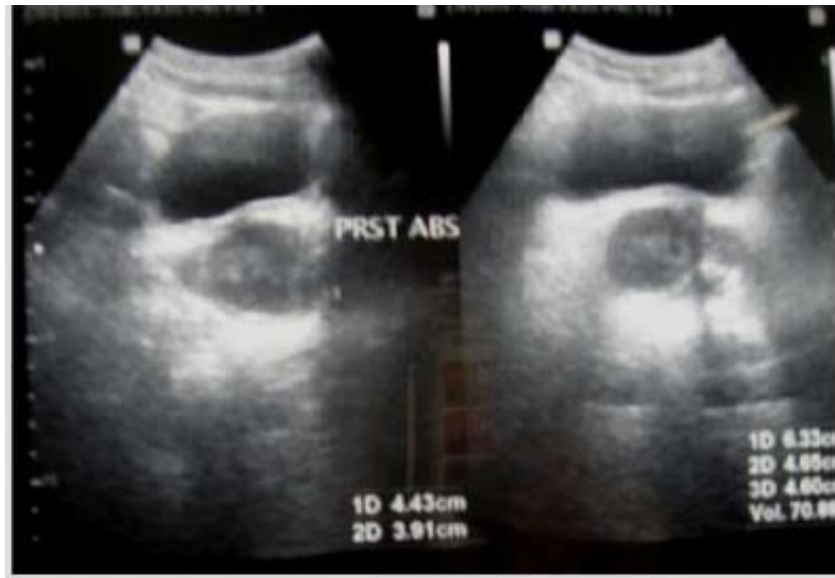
Shows a transabdominal ultrasound image of acute prostatitis'Jameset al., (2008).
